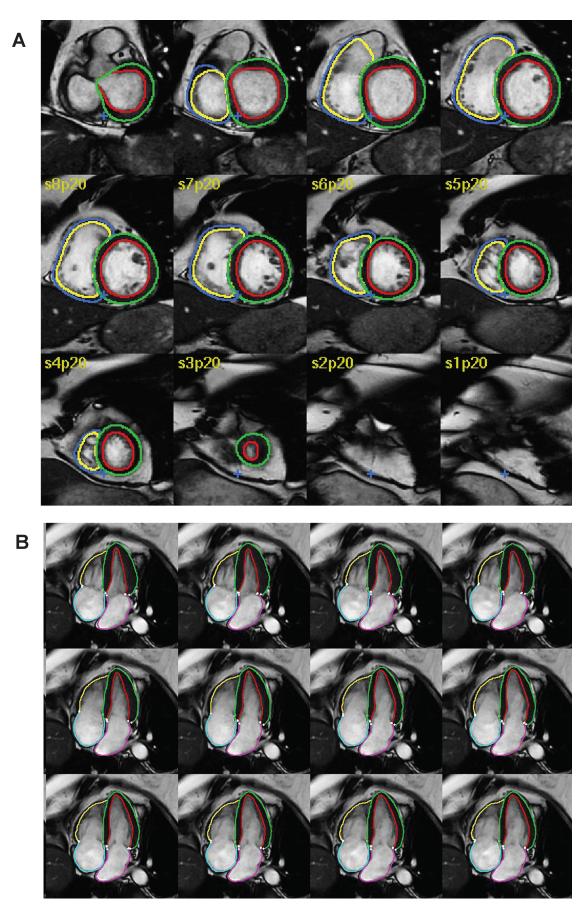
Examples of AI cardiac MRI segmentation. A: biventricular and B: four-chamber segmentation. The coloured contours in green and red show the left ventricular epi- and endocardium, respectively. The contours in dark blue and yellow show the right ventricular epi- and endo- cardium, respectively. The pink and turquoise contours outline the left and right atria, respectively.
